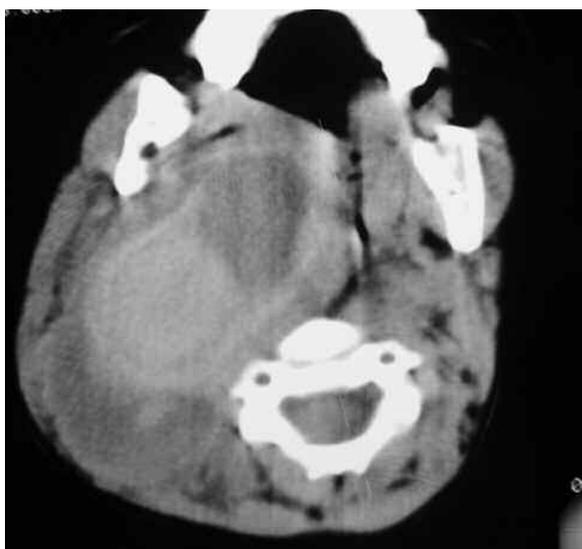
CT without contrast showing the right internal carotid artery pseudoaneurysm and the distortion of the normal anatomy.
